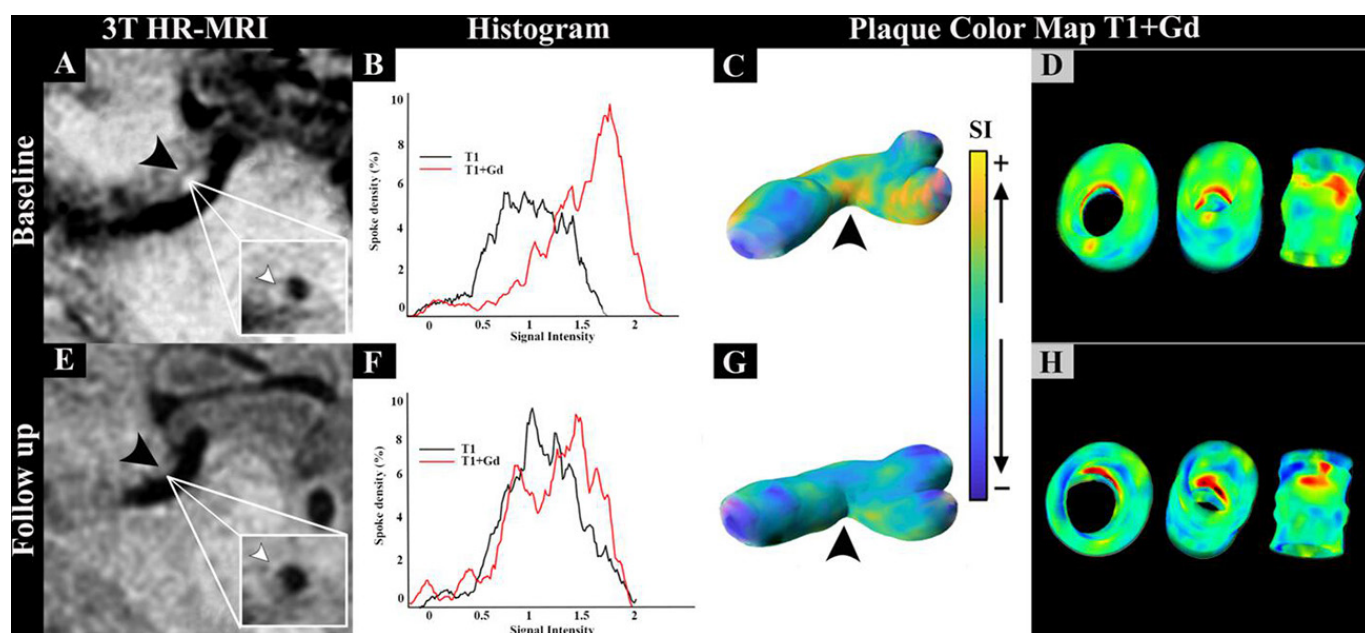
Three-dimensional plaque enhancement analysis. (A) An atherosclerotic plaque in the middle cerebral artery (black arrowhead). The plaque is enhanced with the administration of contrast gadolinium (Gd). This enhancement is visualized as high signal intensity. (B) On histogram analysis the first black curve represents the signal intensity in T1-weighted images. The second red curve shifts to the right as the signal intensity increases in T1-post Gd weighted images. (C, D) The increased Gd enhancement is visualized in 3D color maps. Color maps show high enhancement in areas of luminal stenosis (black arrowhead). (E) The same plaque is imaged at follow-up after initiation of maximal medical therapy (black arrowhead). The plaque enhancement has decreased significantly on visual assessment compared with the baseline plaque (white arrowhead). (F) On histogram analysis, the plaque barely captures contrast and the shift in the post-contrast curve is markedly reduced compared with the baseline histogram. (G, H) Plaque color maps show an objective change in enhancement at follow-up compared with baseline imaging. Areas of increased Gd enhancement (shown in yellow) have almost disappeared (black arrowhead).
